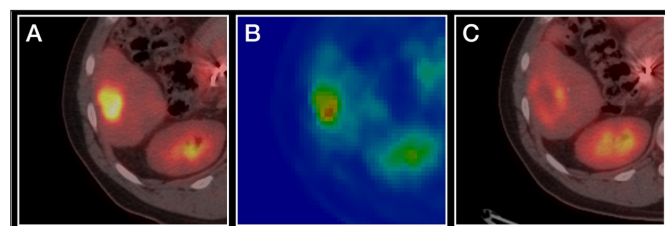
Example of a highly heterogeneous lesion with partial metabolic response to TARE (A) Pre-treatment PET/CT; SUVmax: 14.76, Entropy: 8.01, Kurtosis: 1.83 (B) Textural representation of the tumor (C) Post-treatment PET/CT.
